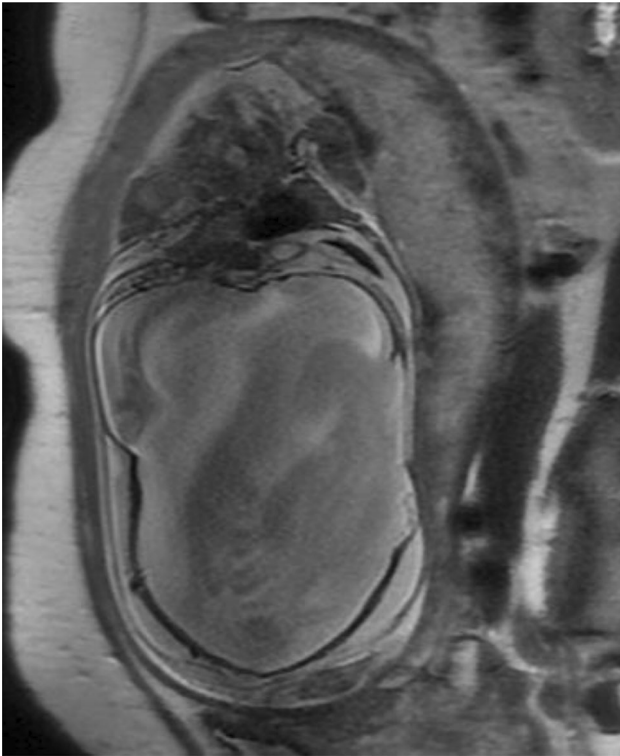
Coronal HASTE MRI sections reveal typically smooth, nonuniform wall thickness of urinary bladder. No evidence of a dilated posterior urethra is noted. Thinned out abdominal wall is seen
